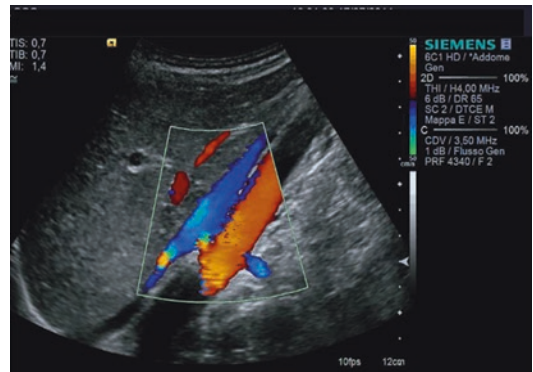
“Banana peel” view. The patient is turned to the opposite decubitus position from the vessel we want to examine, and transducer is oriented longitudinally. The operator locates the aorta first and then moves the transducer in anterior to posterior direction until renal arteries are identified. The right RA moving toward the probe in *red* and the left RA moving away in *blue* color confer to this image the half-peeled banana aspect. Doppler beam angle is close to zero and gives optimal vision of ostial region. Moreover, this maneuver allows precise calculation of RAR and clear identification of accessory renal arteries
